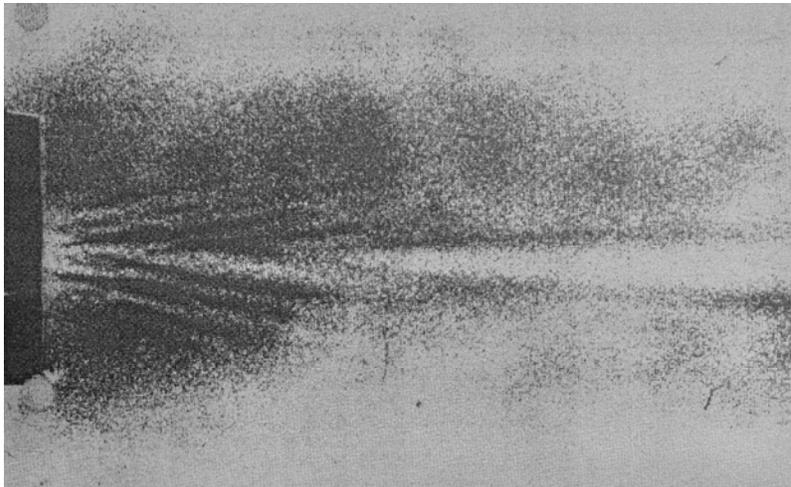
Boyle's dust images of the field of an ultrasound beam from a 178 kHz, 15.3 cm diameter circular source. [31] 1928.
